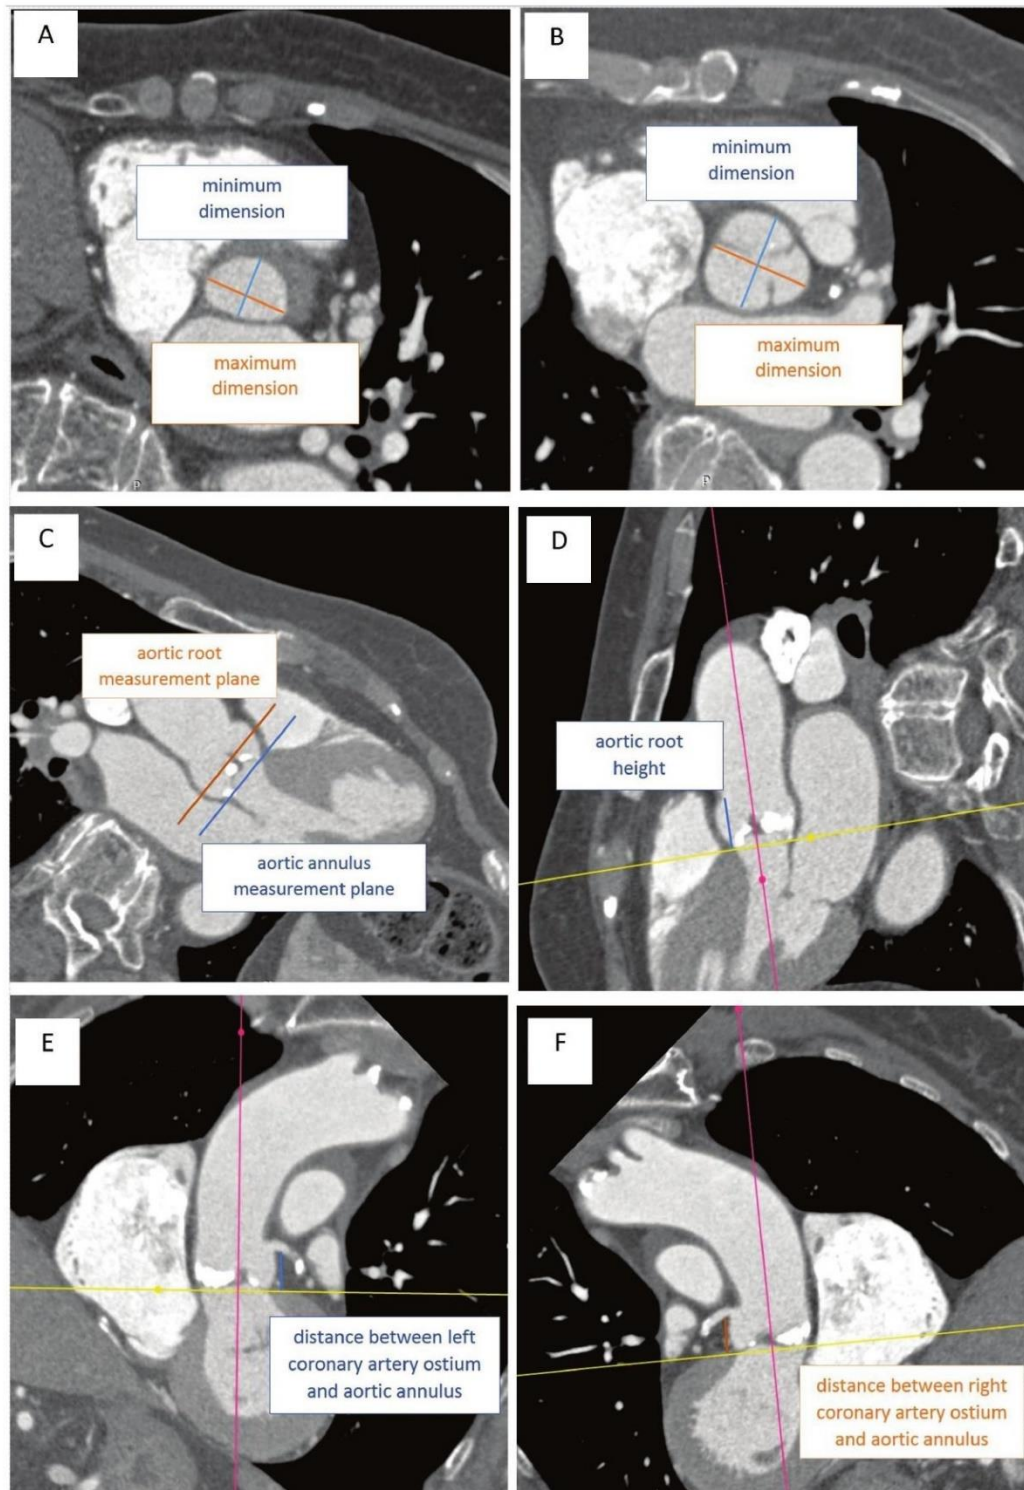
Computed tomography aortic valve measurements: A) maximum and minimum dimension of the aortic annulus (mean dimension of the aortic annulus = (maximum dimension of the aortic annulus + minimum dimension of the aortic annulus)/2); B) maximum and minimum dimension of the aortic root (mean dimension of the aortic root = (maximum dimension of the aortic root + minimum dimension of the aortic root)/2); C) aortic annulus and aortic root measurement planes; D) height of the aortic root; E) distance between the left coronary artery ostium and the aortic annulus; F) distance between the right coronary artery ostium and the aortic annulus
